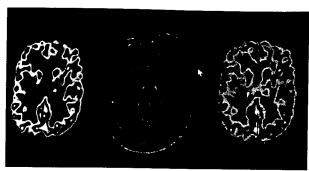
Positron emission tomography (PET) and magnetic resonance imaging (MRI) coregistration using the Chamfer surface-matching technique. The images represented include a PET fludeoxyglucose F18 scan of a patient with PTSD at baseline (left), an MRI resticed to correspond to the PET (center), and a fused PET and MRI image (right). A flducial marker, tilled with fludeoxyglucose F 18, is also visualized (arrow), which was used to check for head movement during the scan.
